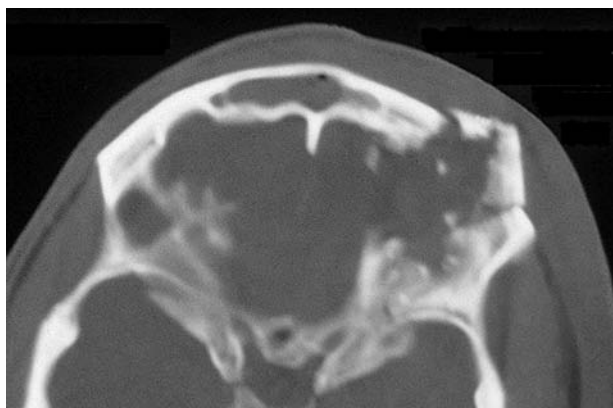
Axial CT of the frontal cranium demonstrating a fracture of the right frontal bone.
